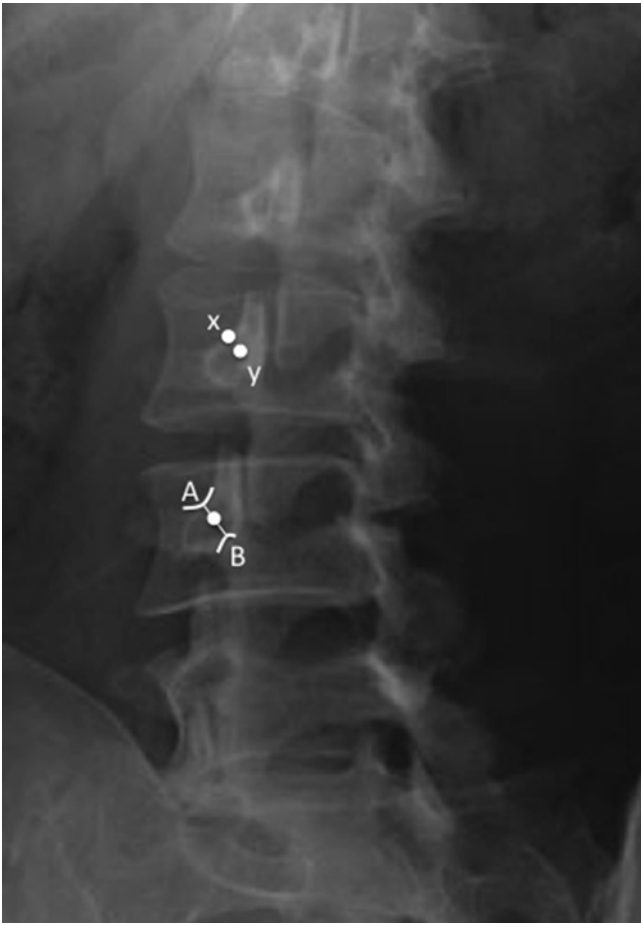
The radiograph shows the target points (*white dots*) for facet medial branch injection. *A* The junction of the superior border of transverse process with the superior articular process. *B* The mamilloaccessory notch. *x* The conventional target which is the junction of the superior border of transverse process with the superior articular process. *Y* The midpoint between *A* and *B* (Reproduced with permission from Philip Peng Educational Series)
